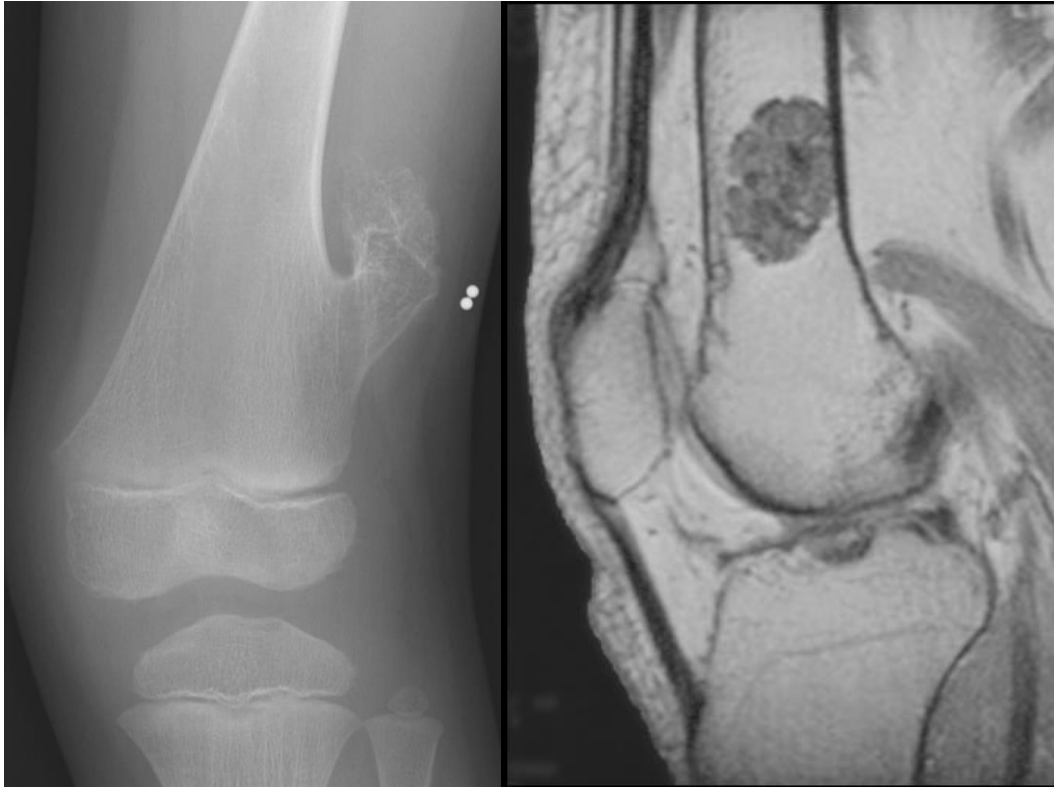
X-ray of typical osteochondroma distal femur to the left and sagittal T1 MRI of an enchondroma with cortical contact on the right. Pictures from Wikipedia.
